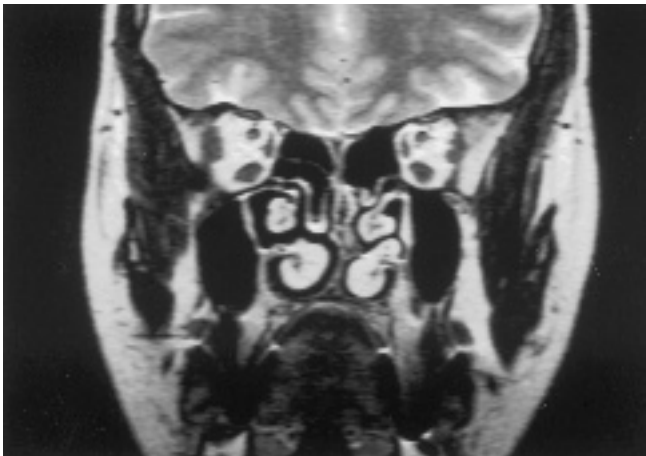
Coronal MRI scan demonstrating the pneumatized superior middle turbinate protruding inferiorly into the region between the middle turbinate and the nasal septum.
